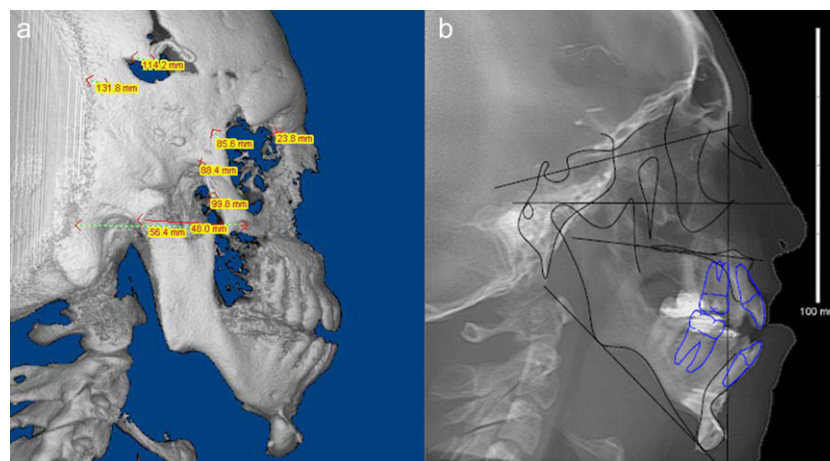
Lateral volumetric shaded surface rendering (a) with 3D cephalometric measurements of patient with corrected craniofacial deformity and comparable lateral cephalometric image with tracing (b) both created from CBCT data. (Images created using Dolphin 3D, Dolphin Imaging and Management Solutions Chatsworth, California, USA)
